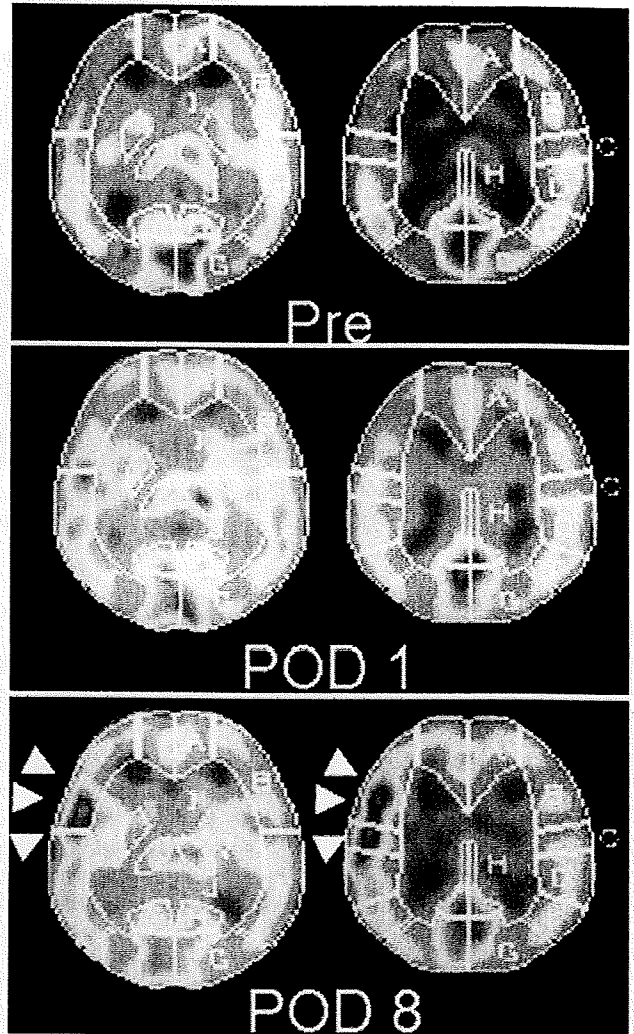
The ^{123}I -IMP-SPECT studies obtained preoperatively (upper), 1 day after surgery (center) and 8 days after surgery (lower). Note the focal intense increase in the CBF at the site of anastomosis (arrowheads in lower).
